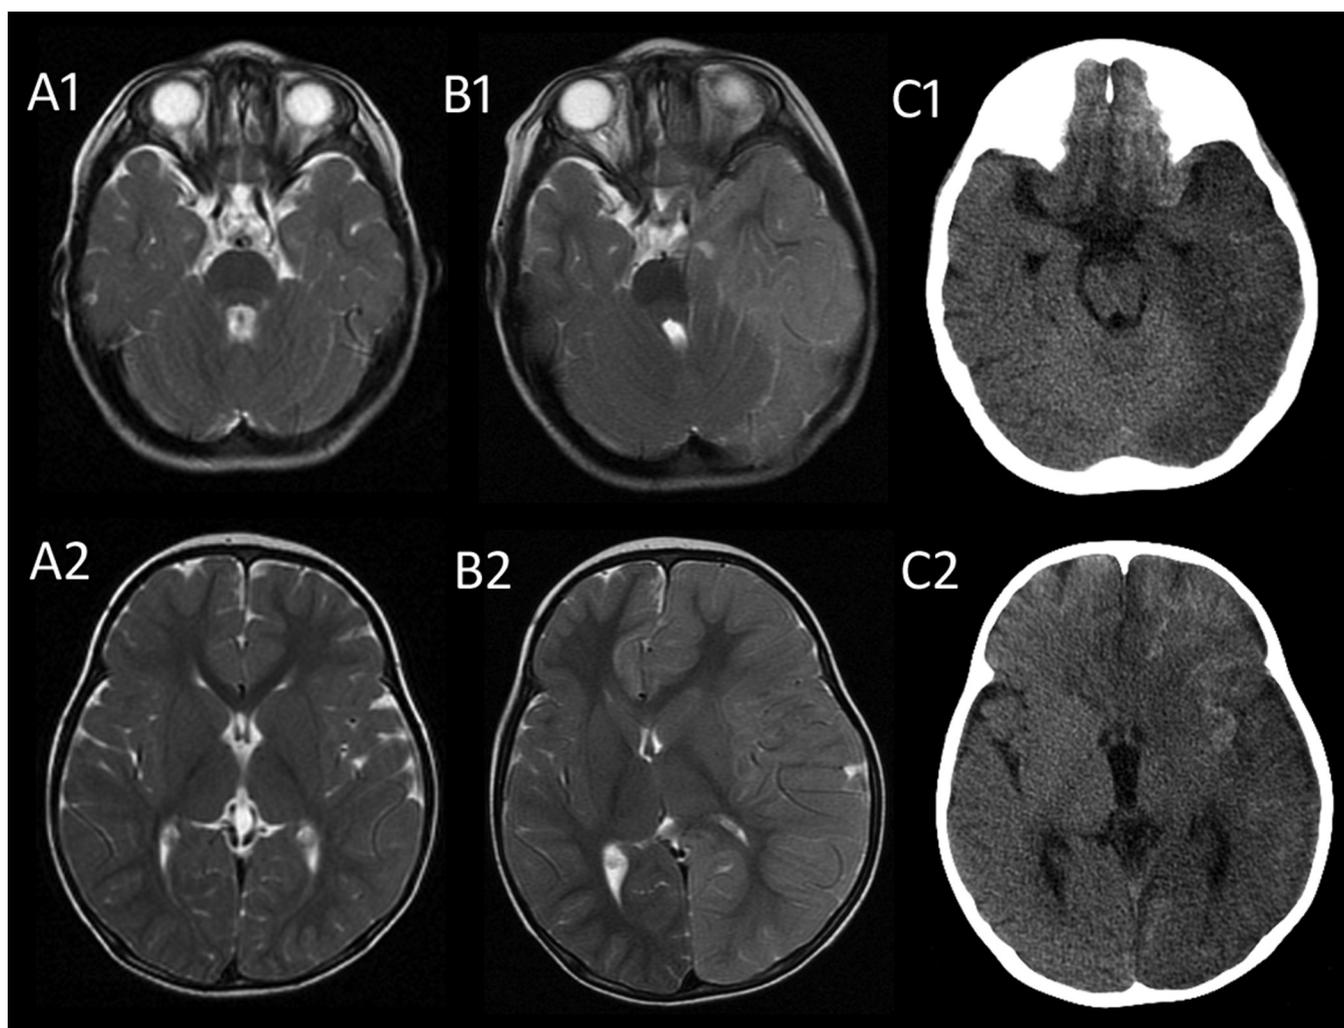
Normal T2WIs (A1 and A2) obtained six months prior to presentation of Patient 2. T2WI (B1) of the acute-phase MRI demonstrates hippocampal herniation, and T2WI (B2) shows obvious swelling of the left cerebral hemisphere with a midline shift. CT scans (C1 and C2) obtained 12 days after the acute-phase MRI showing resolution of swelling. CT, computed tomography; DWI, diffusion-weighted image; MRI, magnetic resonance imaging; T2WI, T2-weighted image.
